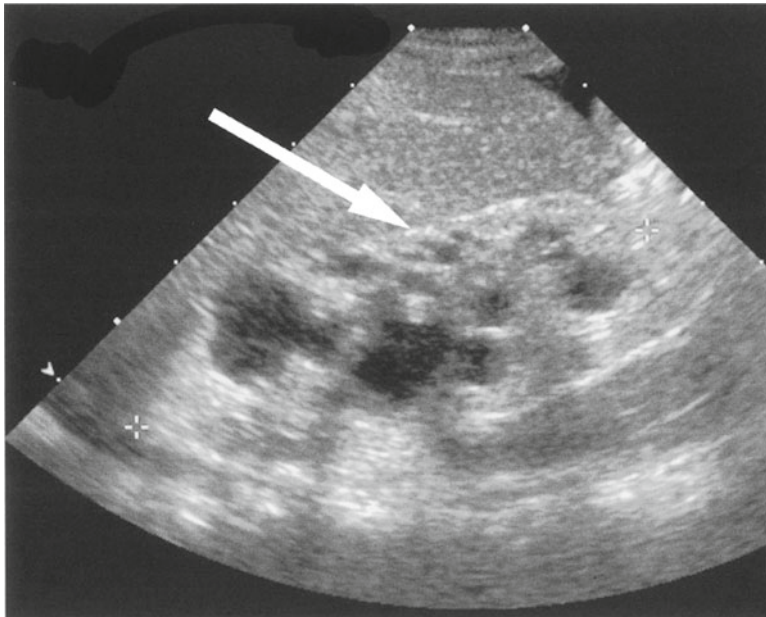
Ultrasound of the right kidney in a 4-day-old infant with PUVs. Note the increased echogenicity compared to the liver and cysts in the periphery suggestive of renal dysplasia
